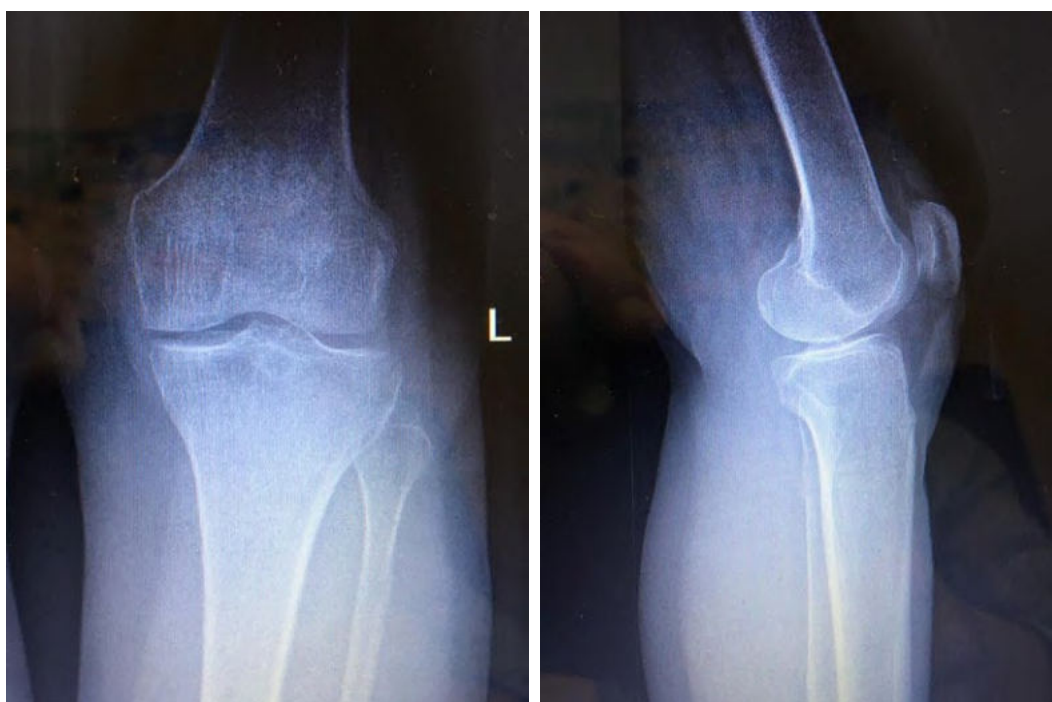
Pre-operative X-Ray of patient's left knee.
